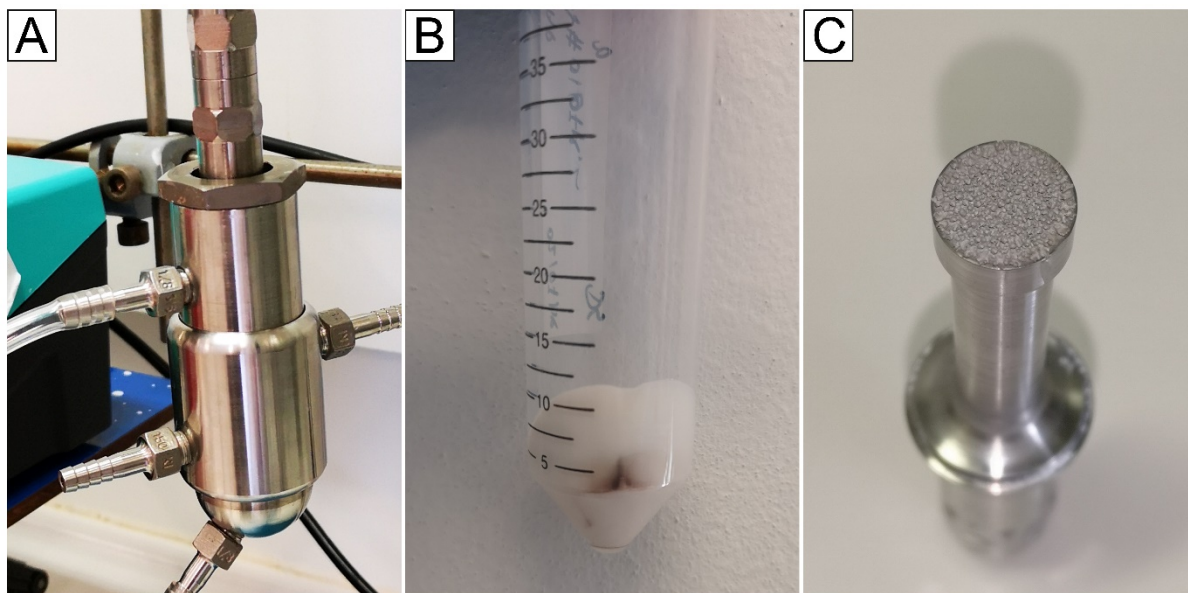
Release of ultrasonic probe debris with the FCR synthesis method. A) Flow cell reactor. B) Debris particles in precipitate after filtration and washing. C) Abrasion of ultrasonic probe.
